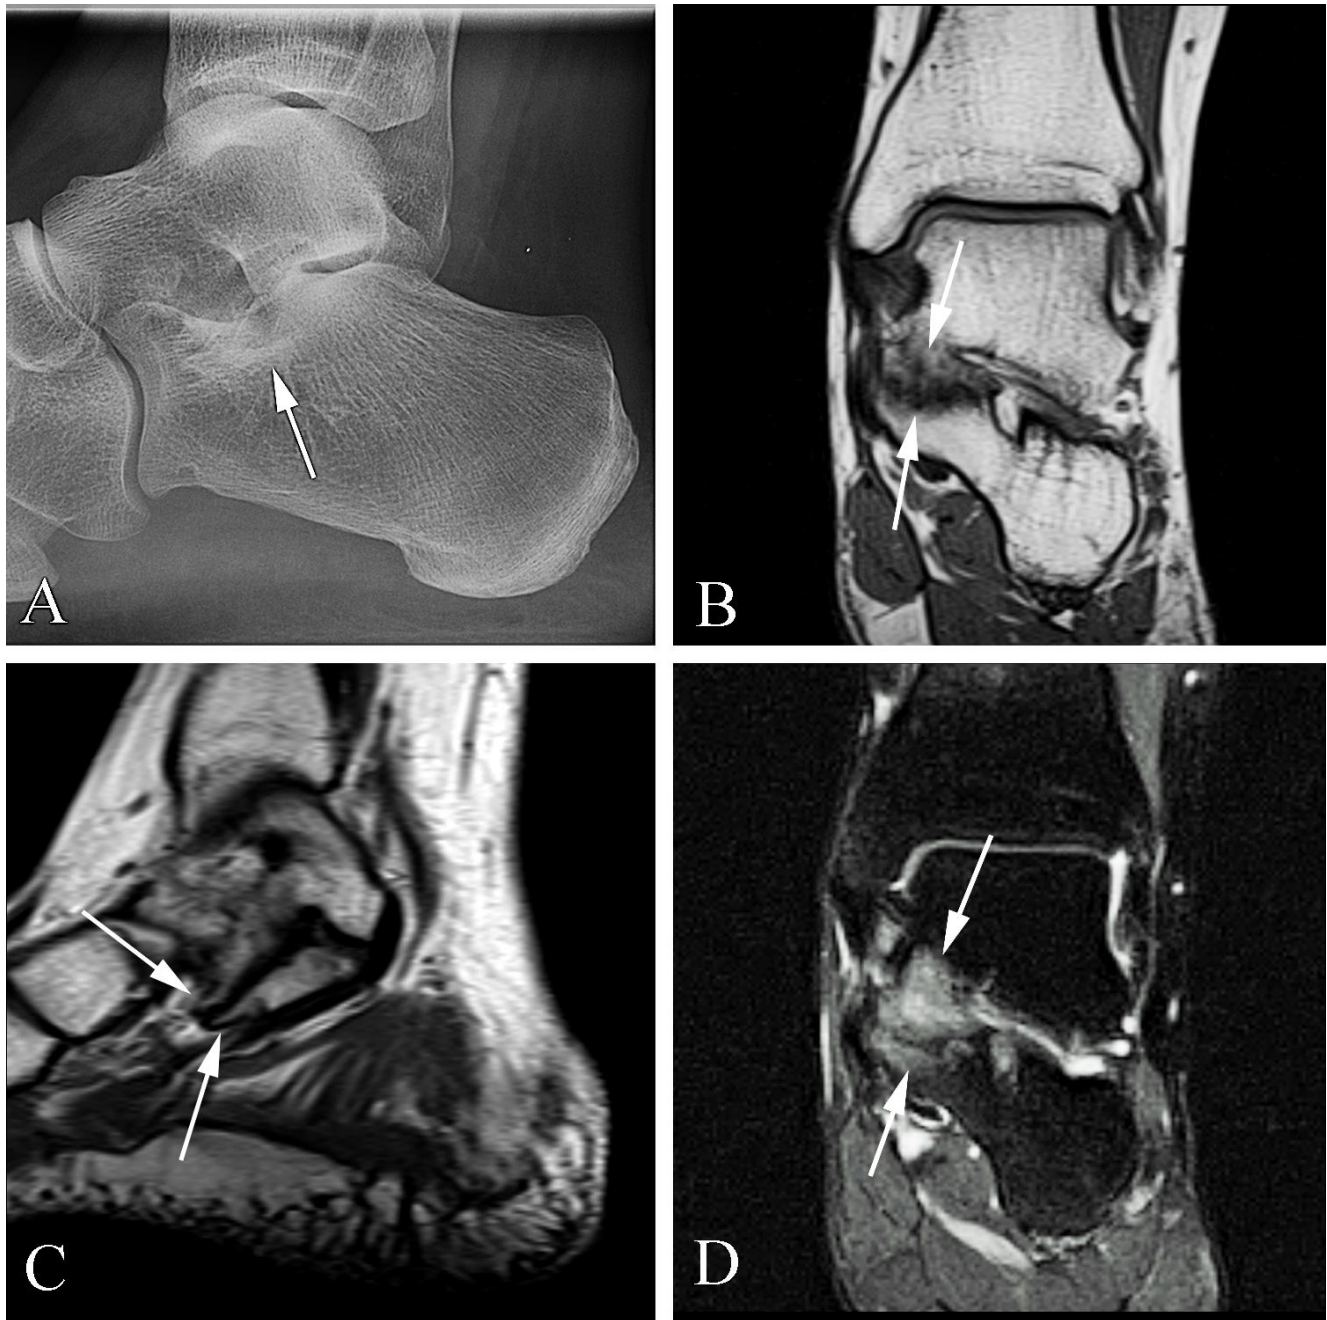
Subtalar coalition in a 32 year old woman with chronic ankle pain. A. Lateral plain film examination shows subtle increased density (arrow) along the margin of the subtalar joint. B. Coronal T1-weighted MR image demonstrates fusion across the medial subtalar joint (arrows) with a broad band of decreased signal intensity compatible with adjacent reactive change. C. Sagittal T1-weighted MR image through the level of the medial subtalar joint shows extensive spur formation along the joint margins (arrows). D. Coronal fat-suppressed T2 weighted image demonstrates increased signal intensity along the joint margins (arrows), compatible with reactive change.
